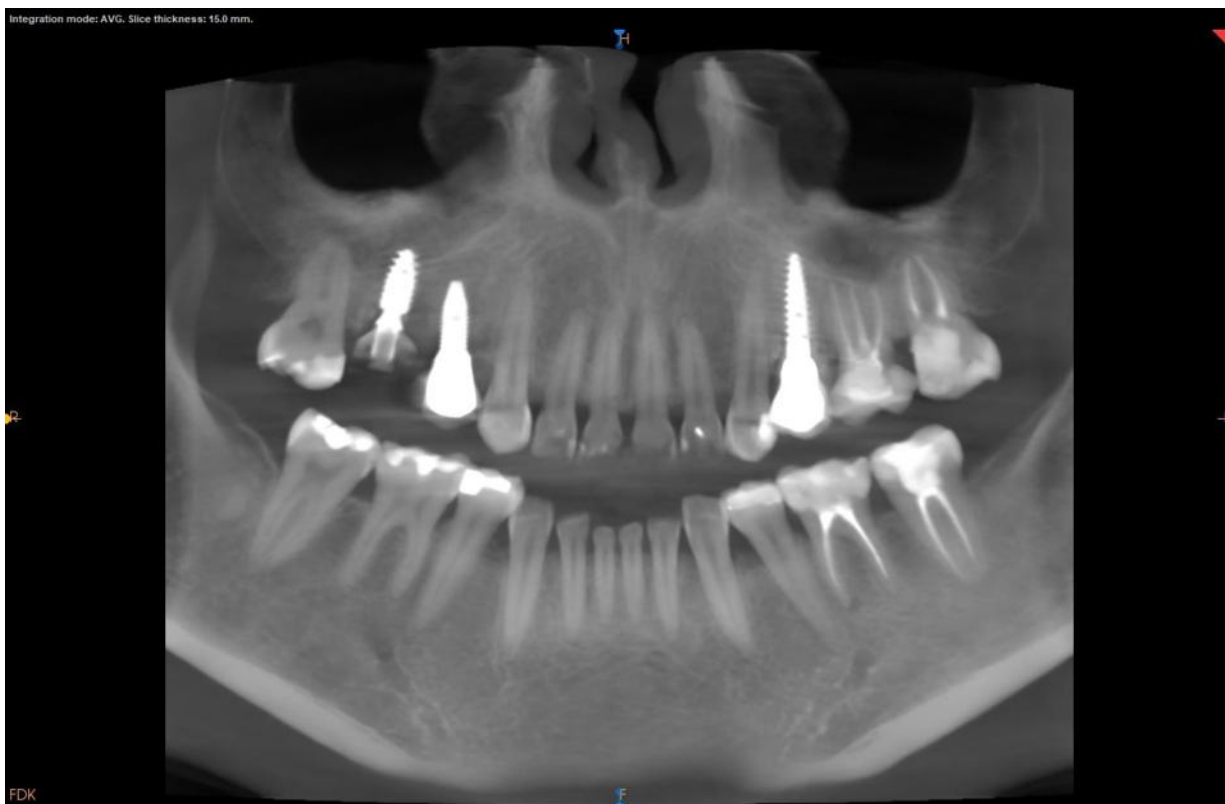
Postoperative panoramic CBCT reconstruction showing the tooth 16 implant and adjacent tooth 15 implant.
